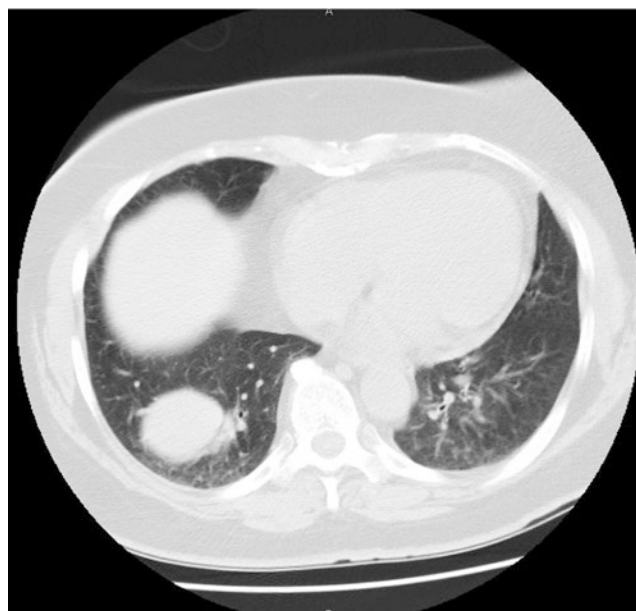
CT image of atypical carcinoid. A well-circumscribed mass is shown in the right middle lobe near the base
